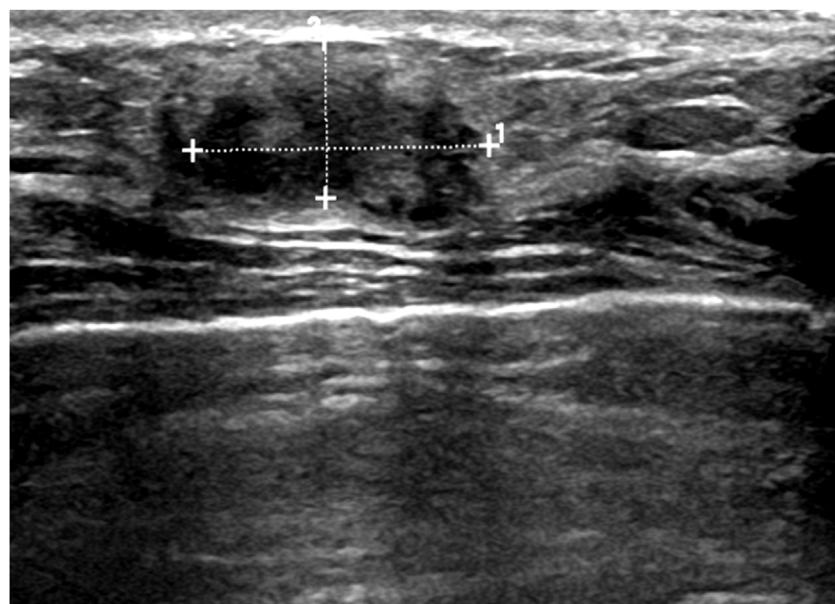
Ultrasound imaging of the right breast showing 9 o'clock hypoechoic anti-parallel mass measuring $1.6 \times 0.8 \times 2.1$ cm, suggestive of highly aggressive malignancy with BI-RADS V.
